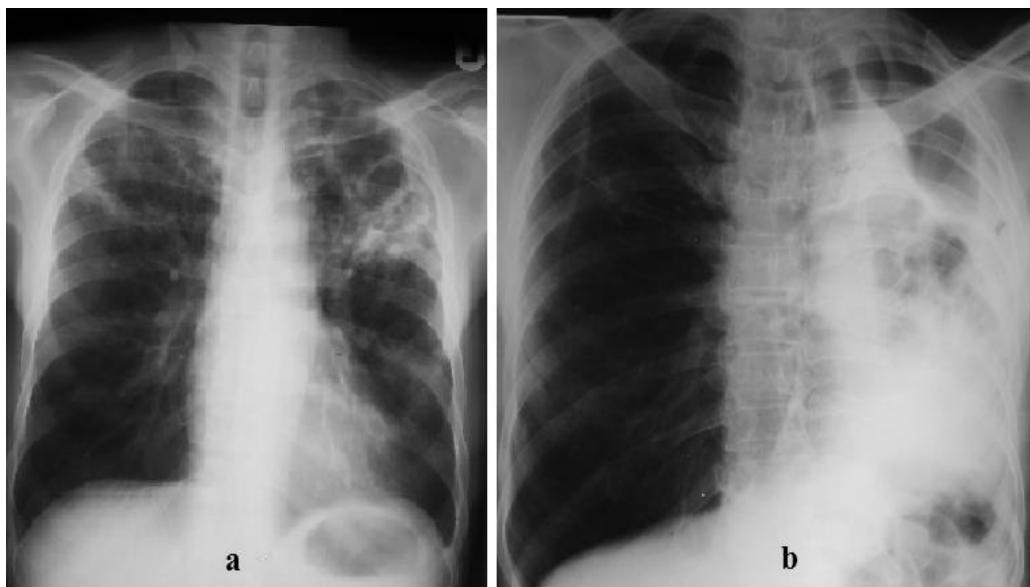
Chest radiograph in a patient with primary pulmonary tuberculosis. There is obstruction of the left main bronchus by enlarged left hilar lymphnodes leading to accumulation of secretions, repeated infection and the collapse of the left lung (destroyed lung syndrome).
